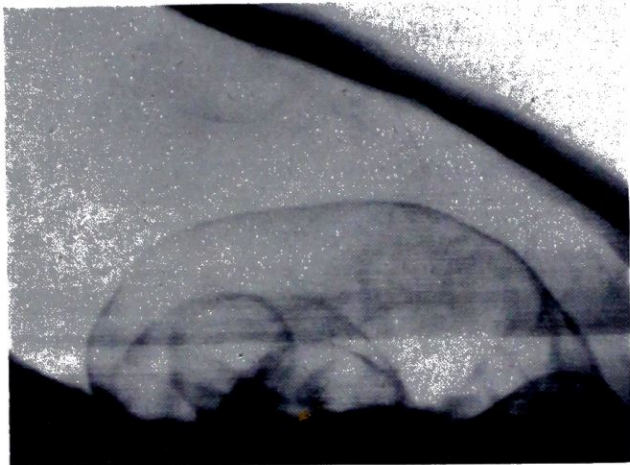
Lateral radiograph showing both distended intestine and gross pneumoperitoneum, following delayed traumatic rupture of the cæcum. (*Gummer and Ranking.*)
